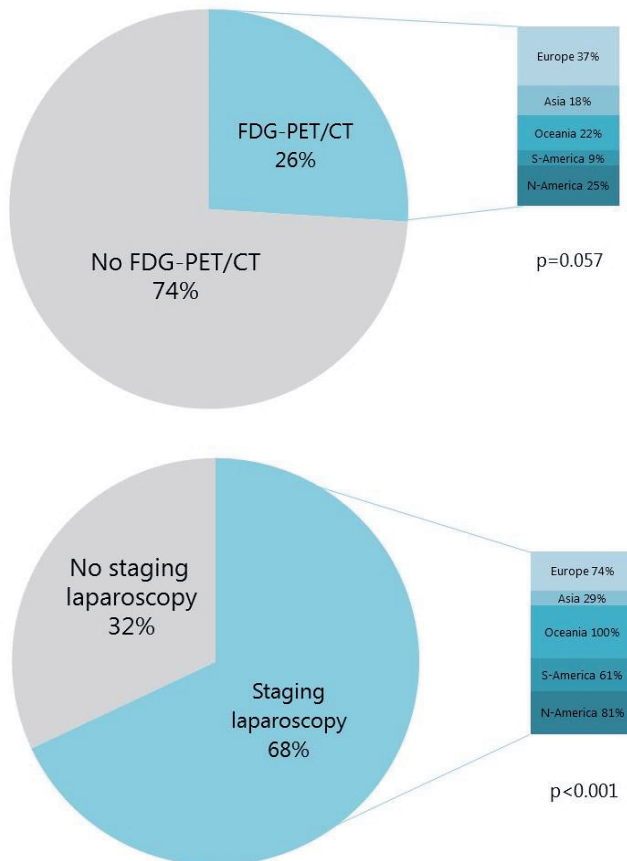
Global usage of FDG-PET/CT and SL in advanced gastric cancer and percentages per continent
